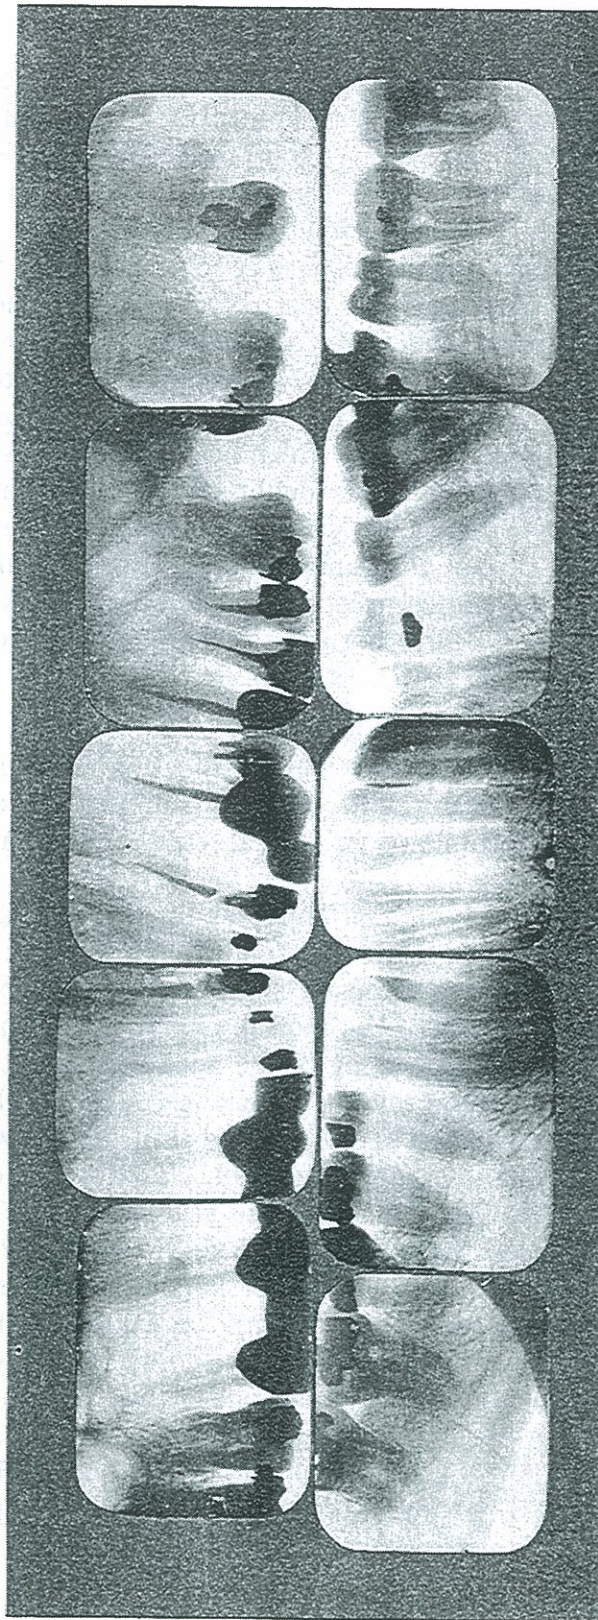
HEMOPHILIA. CASE No. 1024. ROENTGENOGRAPHIC APPEARANCE OF THE TEETH. NOTE THE ABSENCE OF LOCAL REACTION. PATIENT NEARLY DEAD FROM SPONTANEOUS HEMORRHAGE, CHIEFLY FROM GUMS, FOR THREE MONTHS, AND MOST SEVERE ABOUT ROOT-FILLED TEETH. SEE TEXT.
